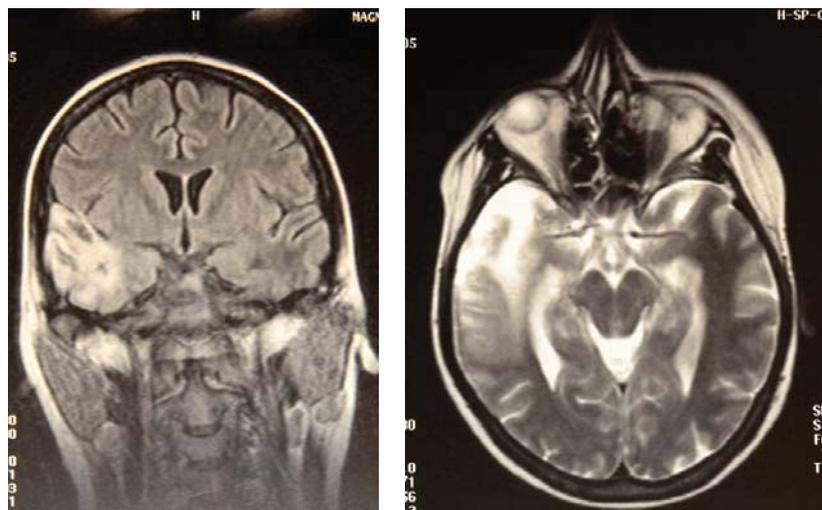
Endocranial magnetic resonance imaging meningoencephalitis of the right temporo-basic region together with encephalomalacia.
